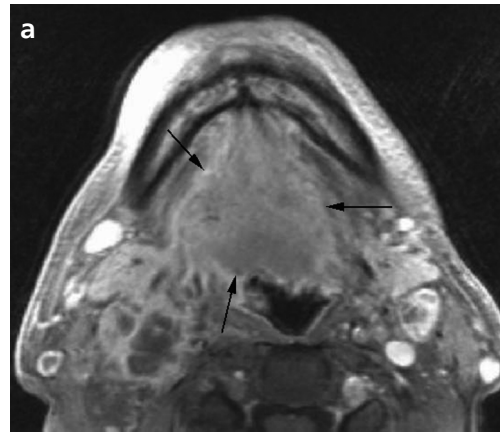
Example of grade 1 posttreatment MRI. (a) Contrast enhanced, pretreatment MRI image (T1-weighted) centered in floor of mouth showing the primary tumor (arrows). (b) Contrast-enhanced, posttreatment MRI image (T1-weighted) of the same patient at the same level as figure 2a, showing anatomic asymmetry (arrow), which was graded 1. Biopsies taken 6 weeks after treatment were negative. The patient remained disease free during a 3.5-year follow-up period.
